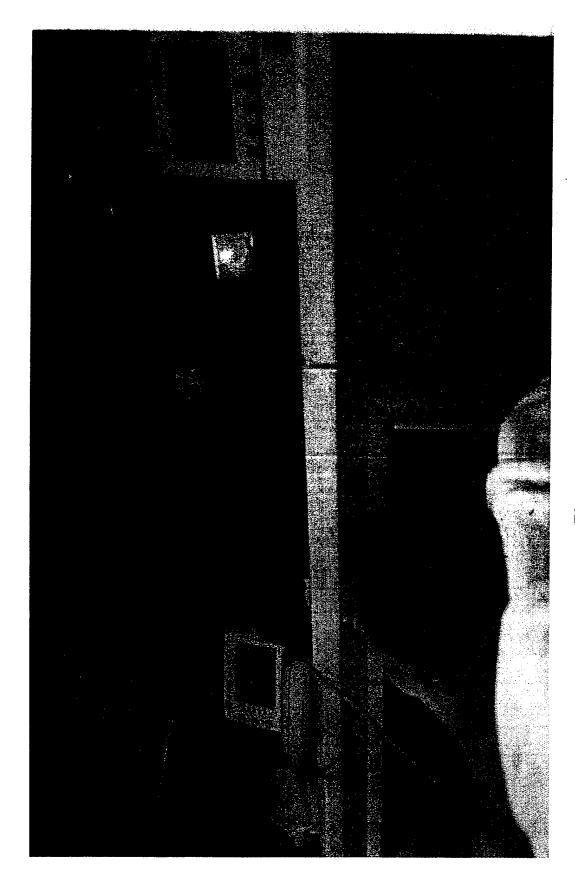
Interior of SAFD LifeLink<sup>TM</sup> Ambulance during Remote Echocardiography Demonstration
